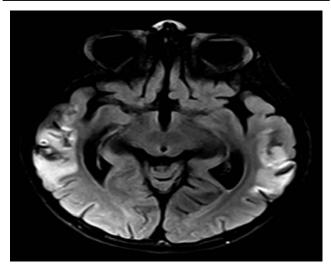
Axial flair MRI showing hyperintense lesions bilateral temporal lobes as well as signs of microhemorrhage.
